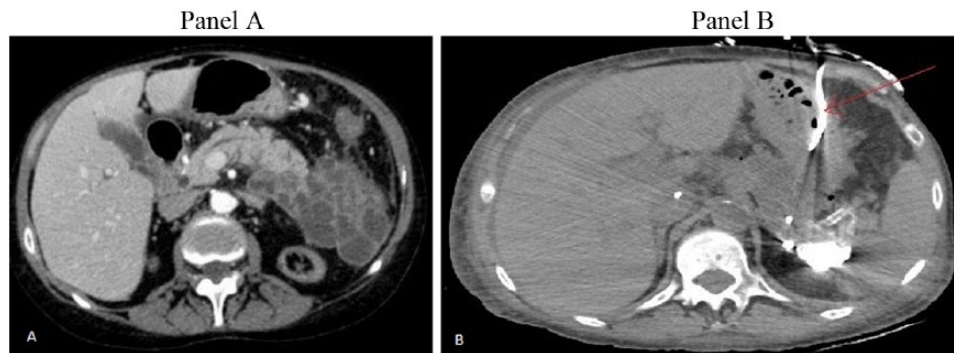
Panel A: pancreatic pseudocyst in abdominal computed tomographic scan. Panel B: abdominal magnetic resonance imaging, percutaneous cystogastrostomy drainage.
